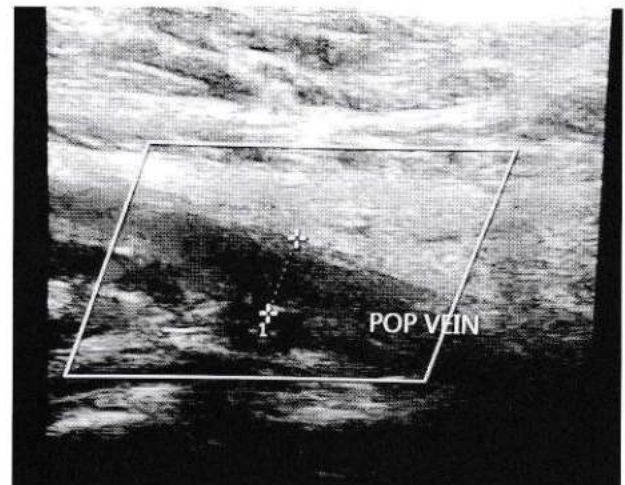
Sonographic image with color Doppler showing acute hypoechoic thrombus within the popliteal vein causing complete occlusion of the lumen.
